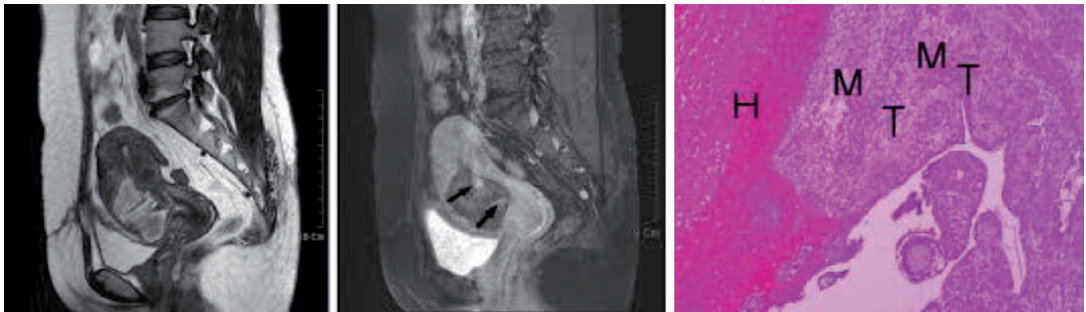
Patient R., 42 years old. Magnetic resonance imaging (on the left): A-sagittal T2-weighted MR image (TR/TE 4000/85 ms) of the pelvic area shows a clearly contoured intramyometric aggregate with high signal intensity. B-sagittal T1-weighted MR image (TR/TE 150/4.2 ms)—after intravenous administration of gadolinium-based contrast medium, shows a hypointense aggregate with focal areas of intensification (the arrows). Morphological examination (on the right): Invasion of trophoblast (T) in the myometrium (M), accompanied by a haematoma (H) [37].
